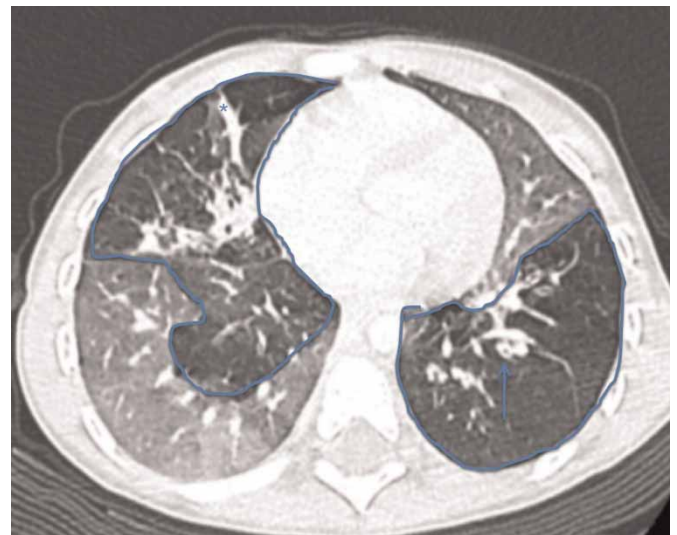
Initial computed tomography.
